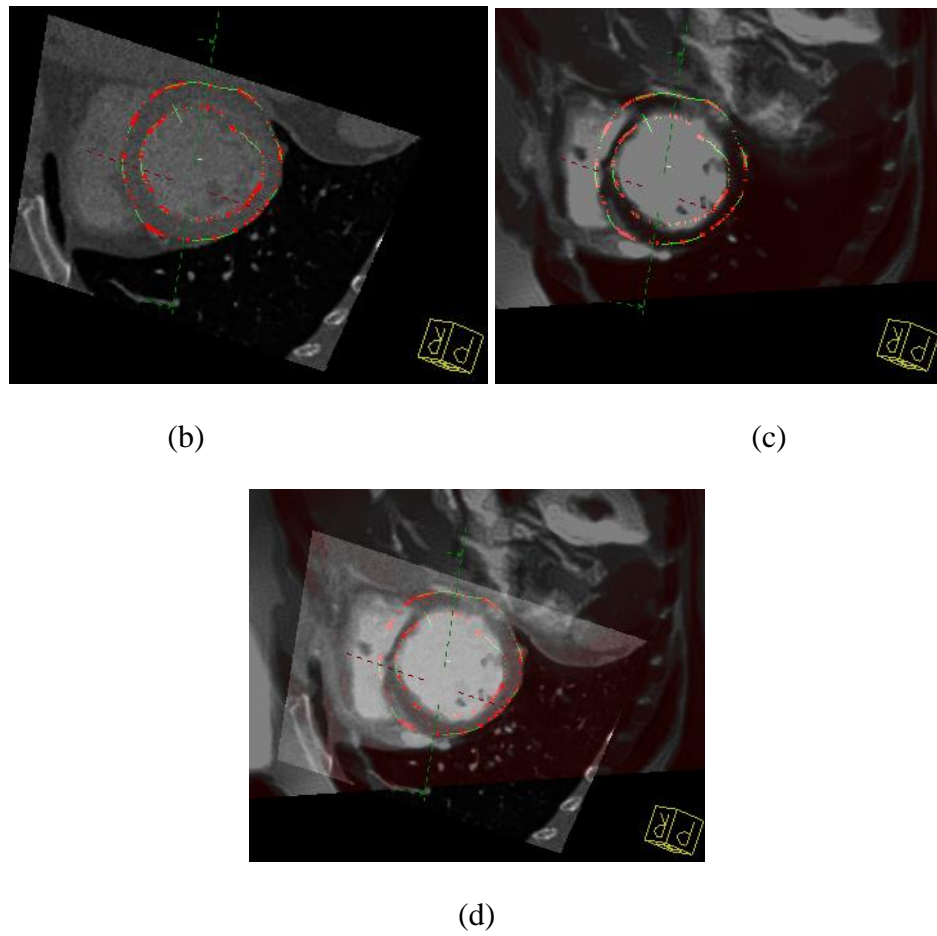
Registration result for Patient 5 showing orientation of CTA volume (a), DEMR slice (b) and the actual correspondence of the two (c).
